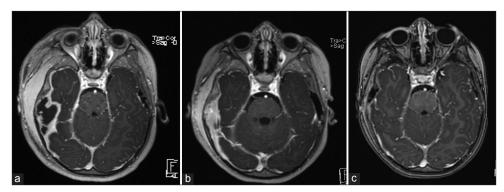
Left to right. (a) Axial T1+ magnetic resonance imaging (MRI) brain demonstrating a right epidural abscess within the middle cranial fossa. (b) Axial T1+ MRI brain on postoperative day 5 showing complete evacuation of the epidural fluid collection with expected persistent regional dural enhancement. (c) Axial T1+ MRI brain obtained 9 weeks postoperatively showed near-complete resolution of the previously seen dural enhancement and no evidence of epidural fluid collection.
